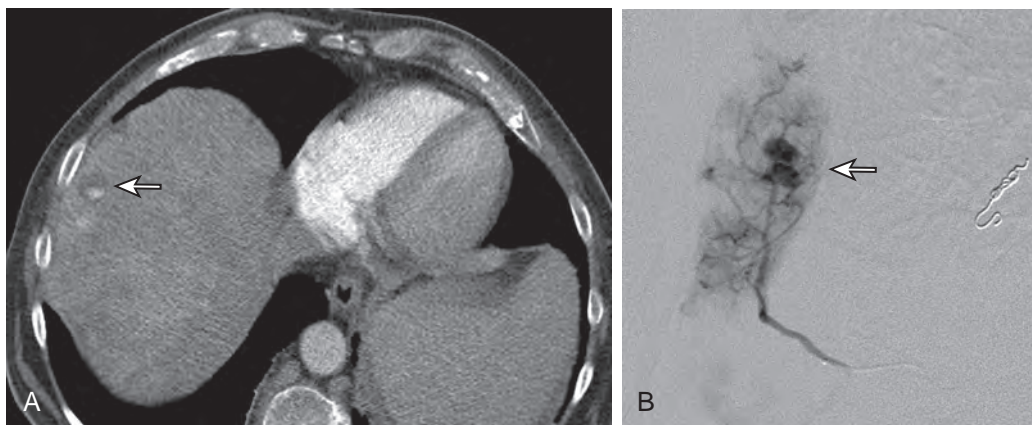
Complication of radioembolization. A. A postcontrast chest CT of a patient who was status post radioembolization reveals pooling of contrast material, suggesting a pseudoaneurysm (arrow). B. Angiogram confirms several small pseudoaneurysms (arrow), which were thought to be radiation induced. They were successfully embolized.
